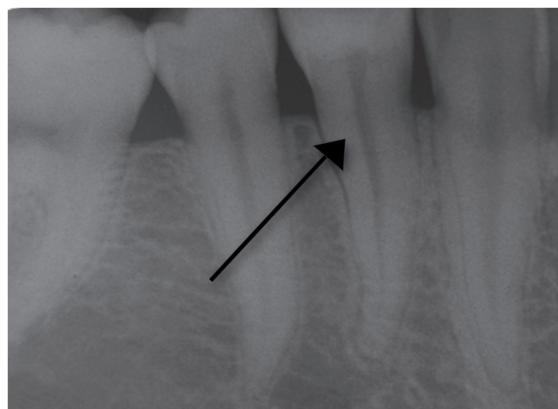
Periapical radiograph and section through CT with arrows indicating oblique fracture of root.
